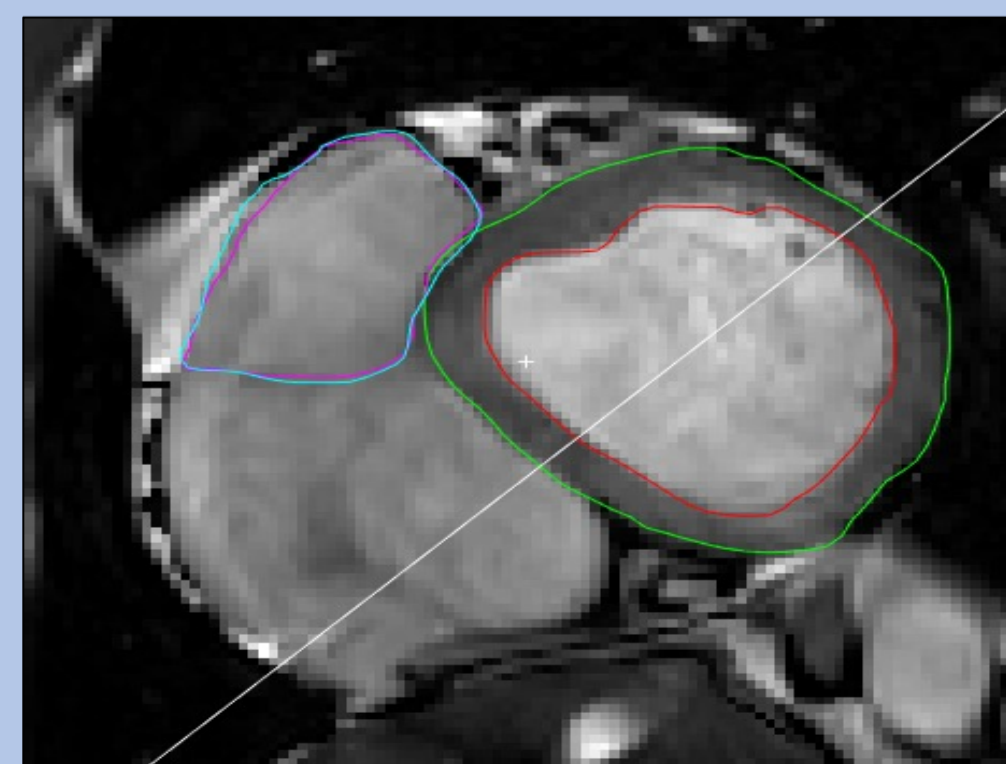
Example of analysis in Segment software of MRI images of the HCM heart
